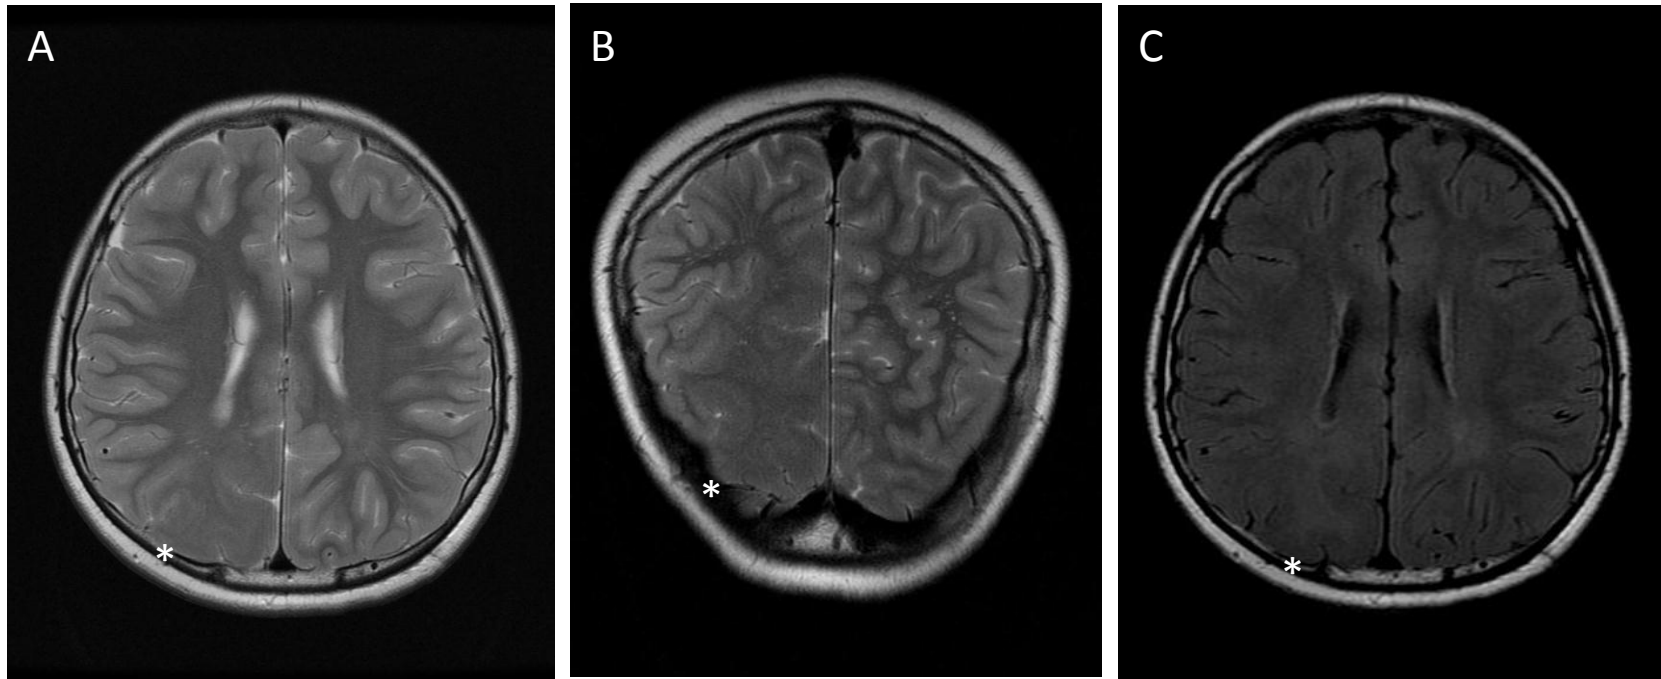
Diffuse type focal cortical dysplasia in an 8-year-old boy. (A) Axial and (B) coronal T2-weighted images show hypointense signal changes in the right occipital cortex. (C) Axial FLAIR image also shows low signal changes in the lesion.
